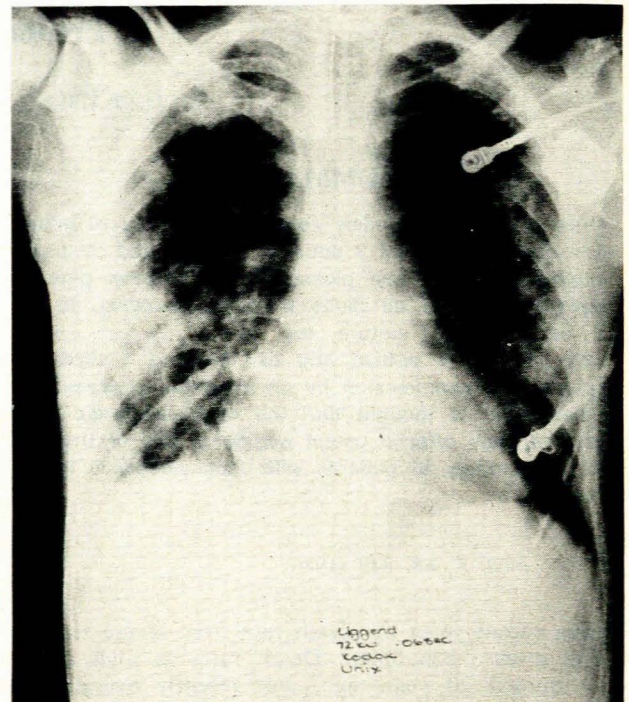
Case 1. Chest radiographs on admission (top) and discharge (bottom).
